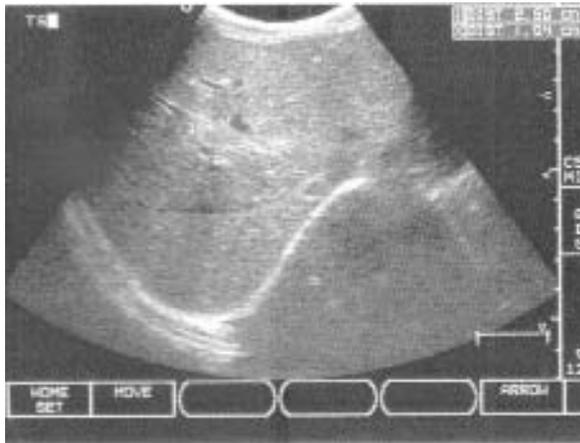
On ultrasonography five weeks after presentation, there is a marked reduction in size of the laceration which is reduced to 2.5 x 1.0 cm.
